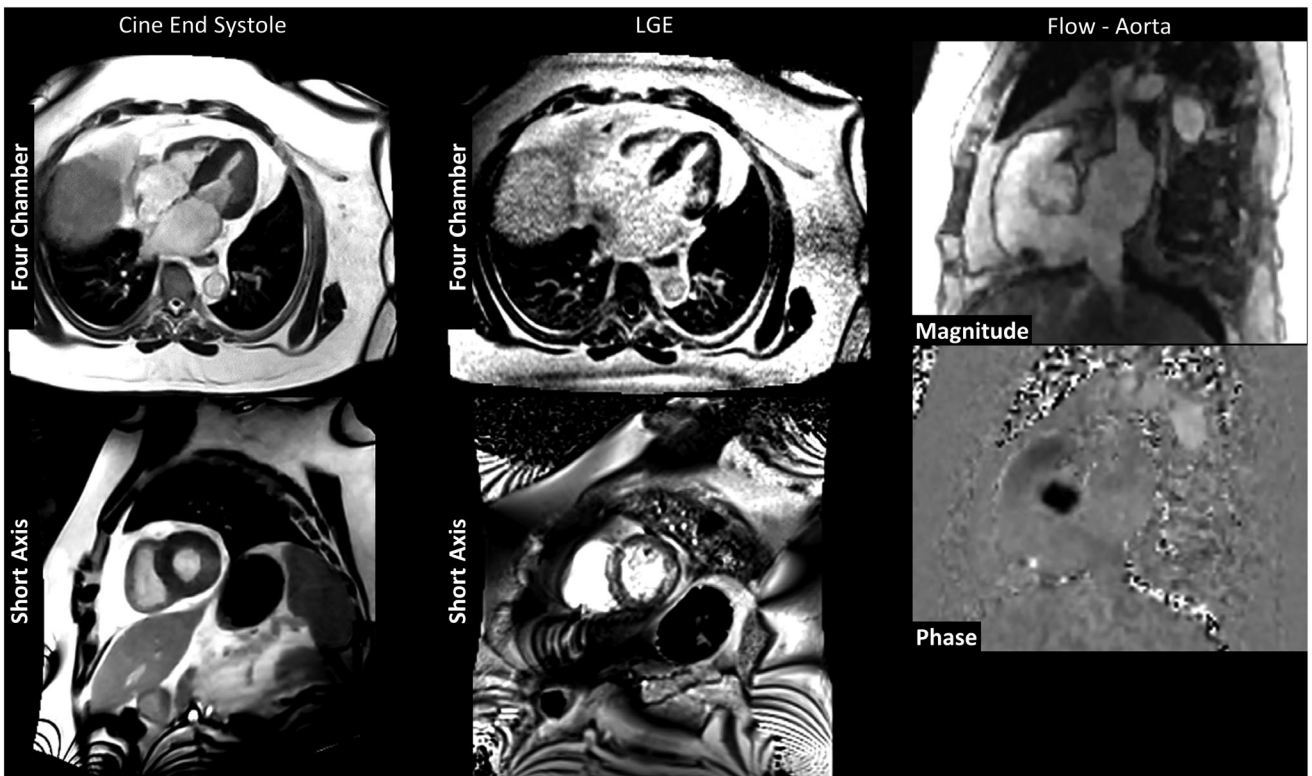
Example images from a commercial 80 cm bore, 0.55 T system in two obese patients unable to undergo cardiac MRI assessment on 70 cm bore systems due to body habitus. Patient A (Male, 61 y.o., 350 lb, BMI 48 kg/m², body surface area 2.6 m²)—Breath-held segmented cine images in four and two-chamber views are shown along with the patient’s echocardiographic images, acquired without and with ultrasound contrast. Multiplanar reformatted images of the thoracic aorta acquired with a non-triggered contrast-enhanced MR angiogram depicts a dilated aorta. Patient B (Male, 65 y.o., 410 lbs, BMI > 57 kg/m², body surface area 2.86 m²)—Breath-held segmented cine (four chamber and short axis view), free-breathing motion-corrected (four chamber) and breath-held segmented (short axis) LGE demonstrating fibrosis, and magnitude and phase images of the aortic root are shown. [Adapted from Varghese et al.²⁰ and Simonetti et al.¹⁴⁸]
